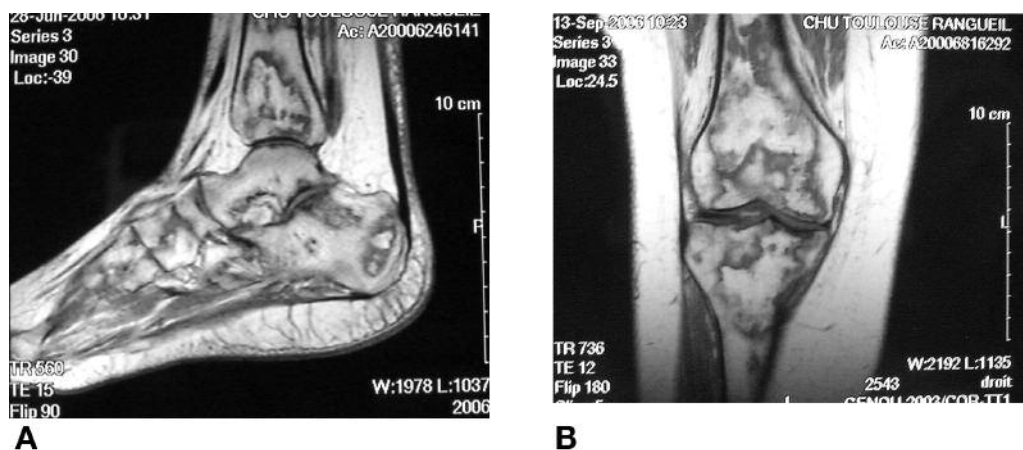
A. Patient 2, MRI of the foot and ankle; T1-weighted sequence shows marrow necrosis of the distal extremity of the tibia, calcaneus, and talus. B. Patient 3, MRI of the right knee; T1-weighted sequence shows marrow necrosis of the femur and tibia.
